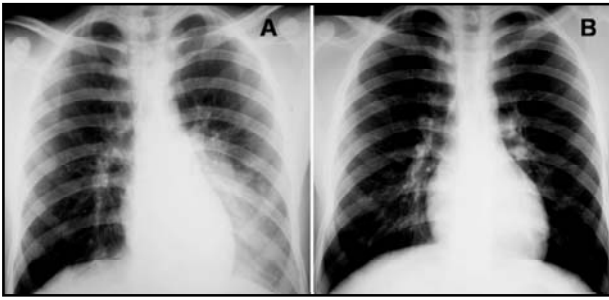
Chest X-ray. A: At first admission, prior to antibiotic treatment. B: After the treatment, at the second admission.
